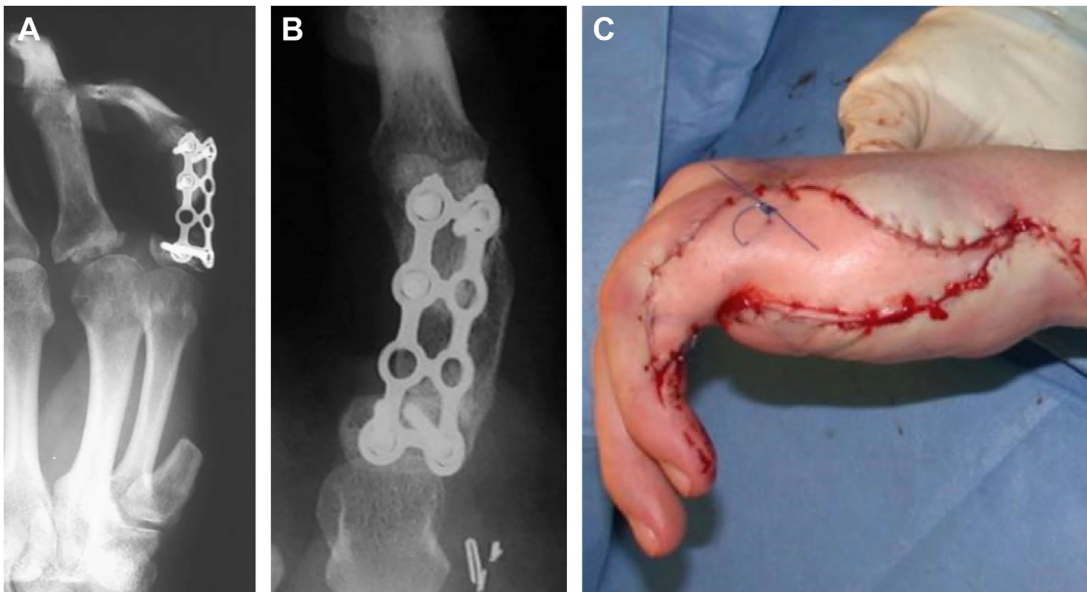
Example of MFC reconstruction of a phalangeal nonunion. (A) Radiograph of ring finger proximal phalangeal nonunion after initial plating and subsequent failed cancellous bone grafting. (B) AP radiograph demonstrating healing. The corticoperiosteal MFC was used with the periosteum oriented ulnarly. (C) The skin segment was inset on the lateral aspect of the hand. (From Assi PE, Giladi AM, Higgins JP. Chapter 18: Medial Femoral Condyle Corticocancellous and Osteochondral Flaps. In: Wiesel SW, Albert T, eds. Operative Techniques in Orthopaedic Surgery. 3rd ed. Lippincott Williams & Wilkins; 2021. p. 3138-3152.; with permission. (Figure 5 in original).)
